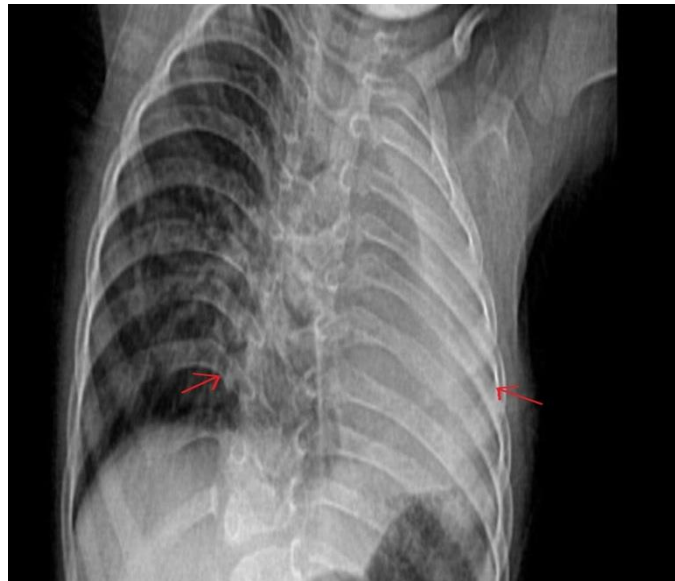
Chest X-ray PA view showing left hemithorax white-out, with scoliosis showing convexity towards right and hyperinflation of the contralateral lung
